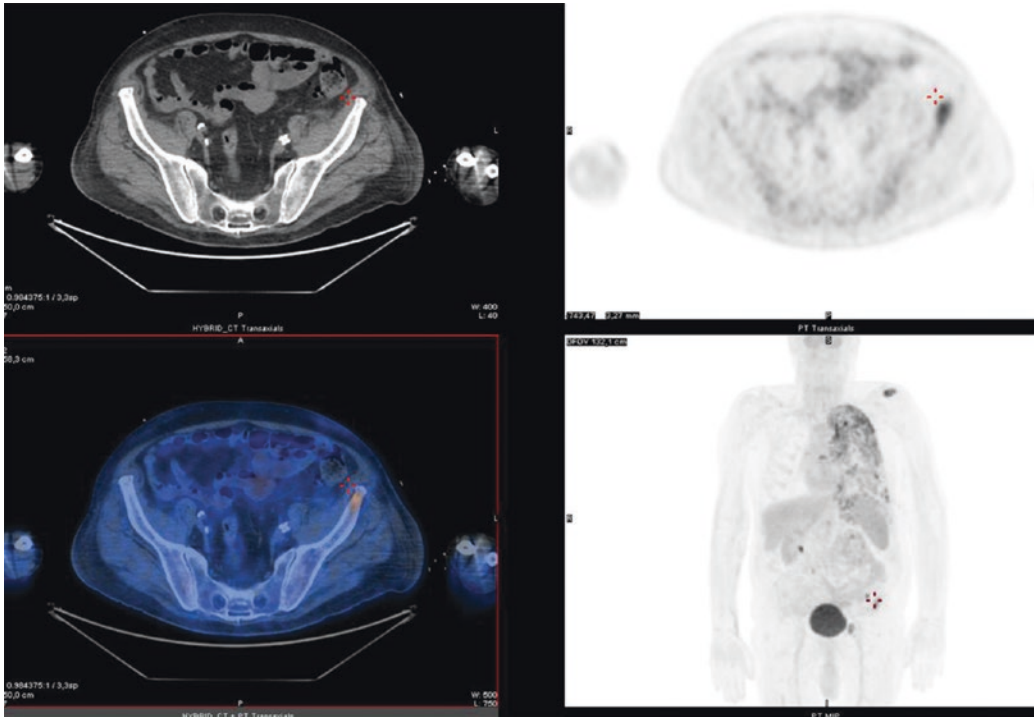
PET/CT is useful in detecting distant occult metastases. In this patient we observe an occult metastasis located on the left iliac wing
